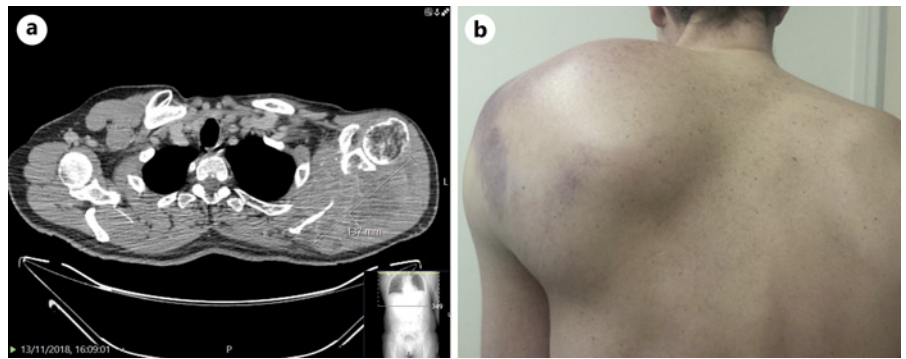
a Left scapular metastasis measuring 137 mm in long axis shown in the sorafenib baseline CT scan (November 2018). b Patient's left shoulder tumour before starting first-line sorafenib in February 2019.
